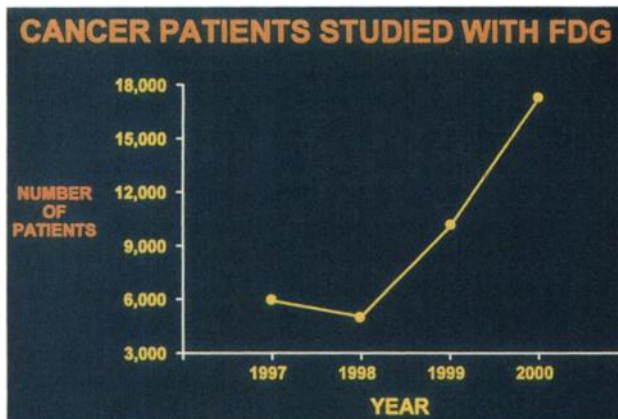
The number of patients with cancer studied with FDG summarized from the presentations at the SNM meeting.
